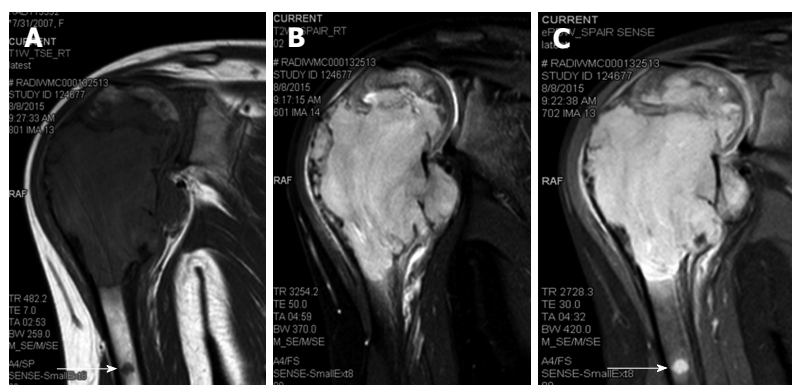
Oblique coronal turbo spin-echo T1-weighted (A), turbo spin-echo T2-weighted fat-suppressed (B) and proton-density-weighted fat-suppressed (C) magnetic resonance imaging images of the right shoulder showing a solid expansile intramedullary mass replacing the normal marrow fat; hypointense on T1-weighted images, hyperintense on T2-weighted images. A cortical break in medial upper humeral diaphysis with extension into soft tissue noted. Note another skip lesion in the humeral shaft with similar signal characteristics (white arrow).
